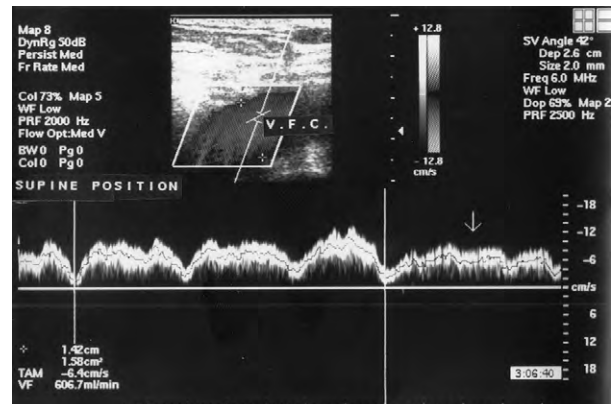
Blood flow in the femoral vein in spectral Doppler mode during breath-holding on expiration (arrow).
